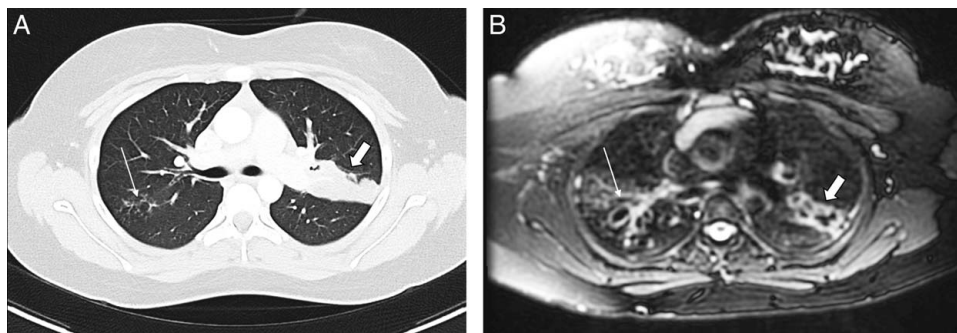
A 10-year-old with cystic fibrosis and progression of disease detected on follow-up MRI 2 years later. A, Axial enhanced lung window setting CT image shows tree-in-bud nodularity (thin arrow) in the right upper lobe and bronchiectasis with mucoid impaction (thick arrow) in the left upper lobe. B, Axial nonenhanced T2-weighted fat suppressed MRI obtained 2 years later shows worsening right upper lobe bronchiectasis (thin arrow) and persistent left upper lobe bronchiectasis (thick arrow) with reduced mucoid impaction compared with prior CT.
